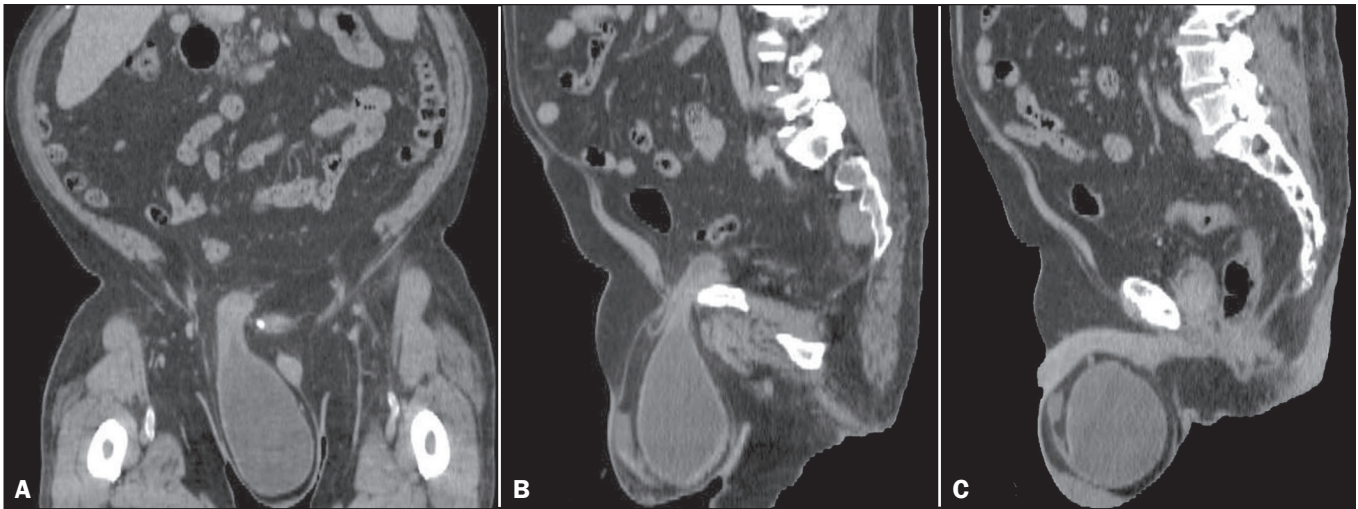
CT images of the abdomen and pelvis, in a coronal view (A) and in sagittal views (B,C), showing a massive right-sided scrotal cystocele.
